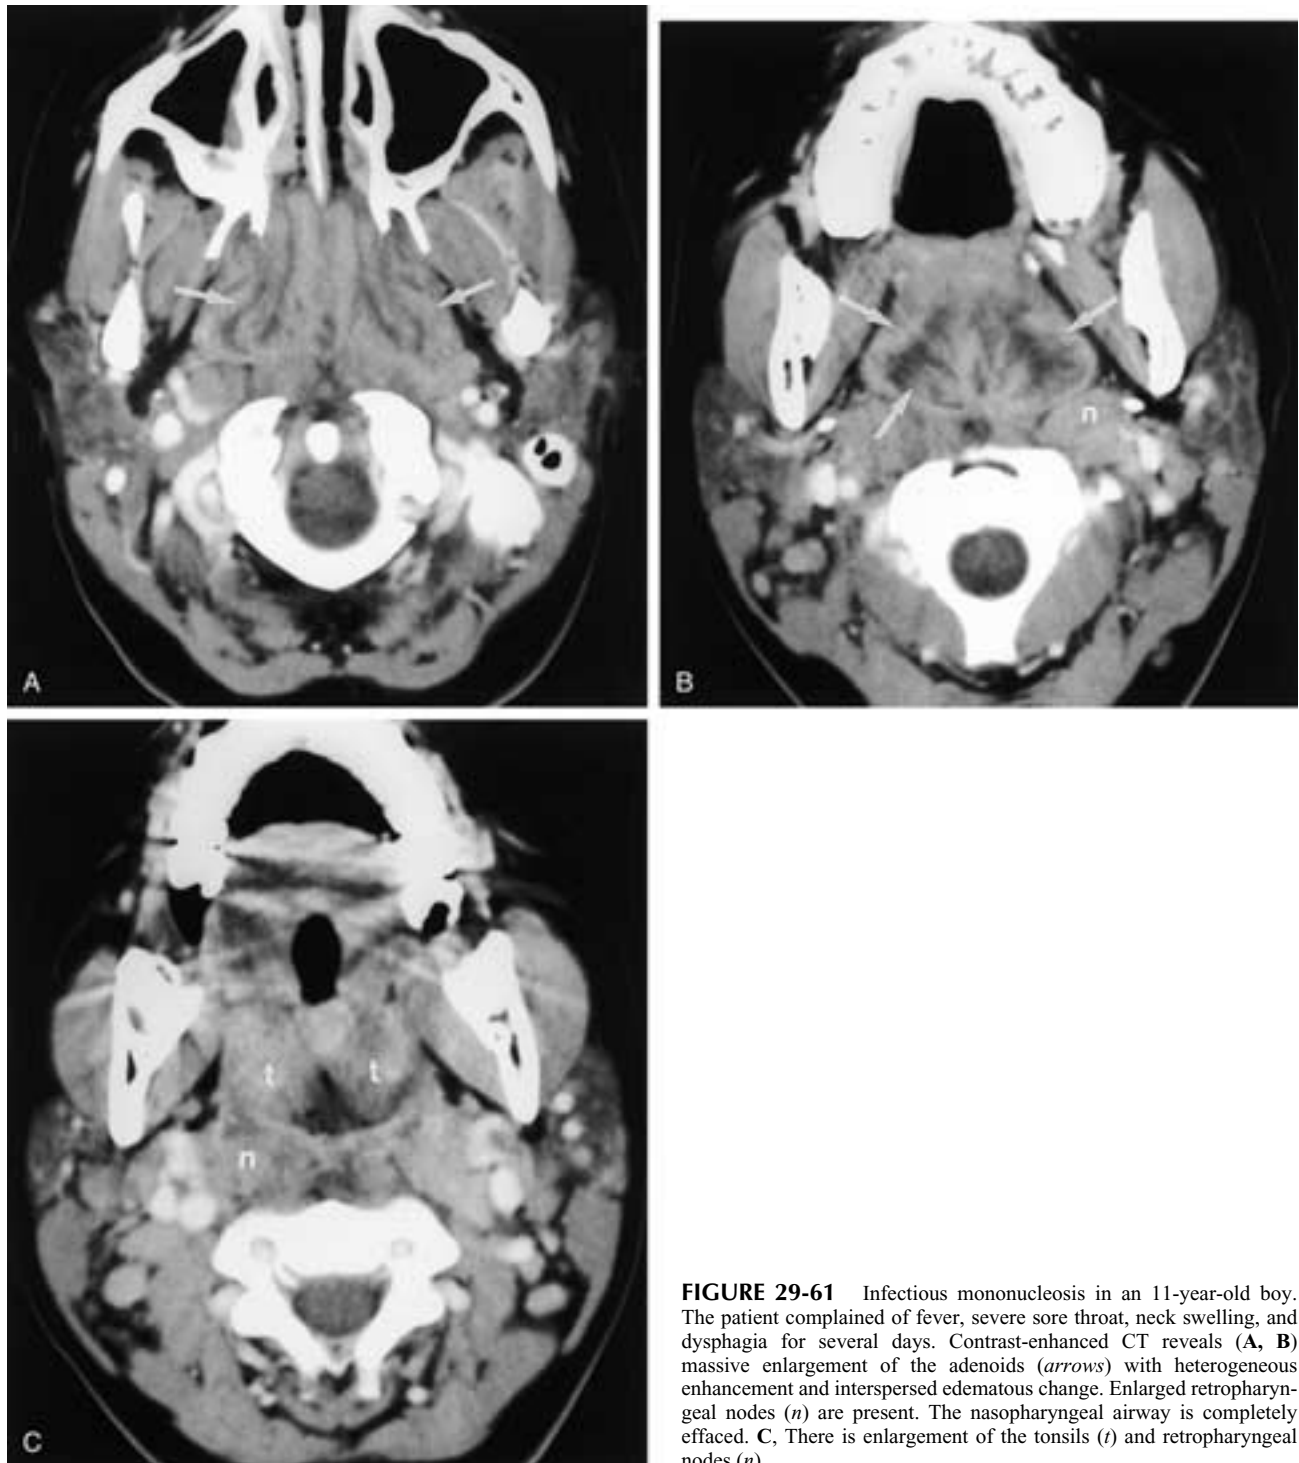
Infectious mononucleosis in an 11-year-old boy. The patient complained of fever, severe sore throat, neck swelling, and dysphagia for several days. Contrast-enhanced CT reveals (A, B) massive enlargement of the adenoids (arrows) with heterogeneous enhancement and interspersed edematous change. Enlarged retropharyngeal nodes (n) are present. The nasopharyngeal airway is completely effaced. C, There is enlargement of the tonsils (t) and retropharyngeal nodes (n).
